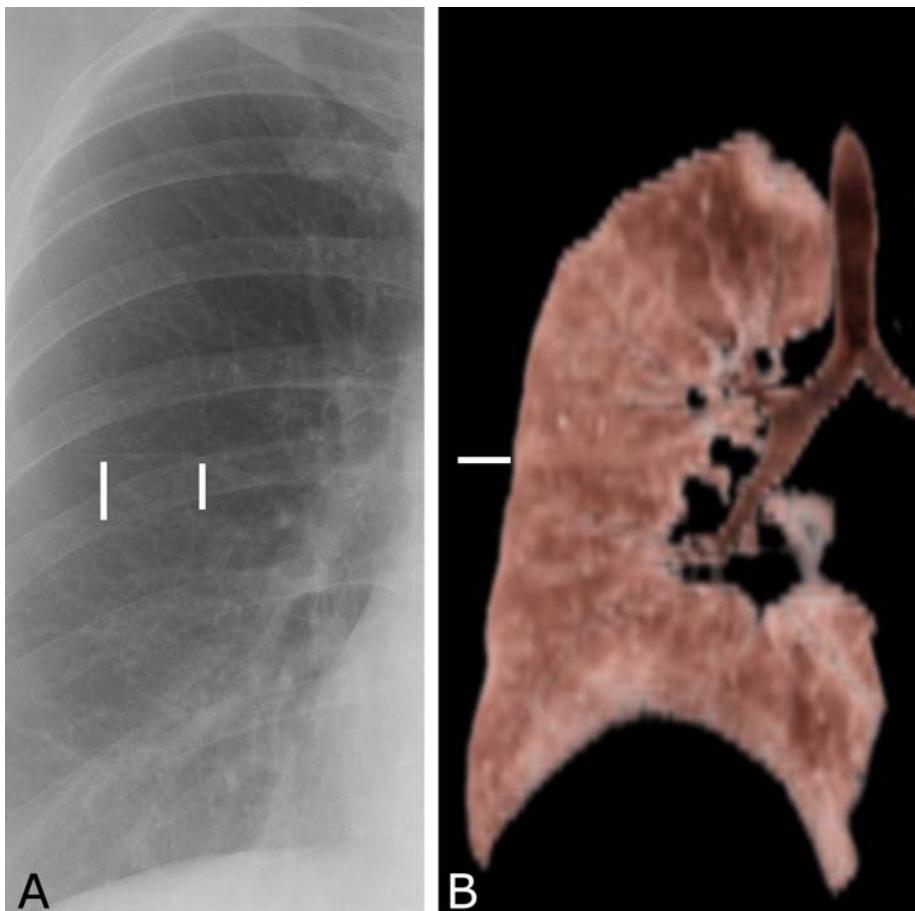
Lungs. A. Frontal chest radiograph shows the minor fissure which separates the right upper lobe from the right middle lobe. B. Volume rendered CT image of the right lung shows the same structure.
